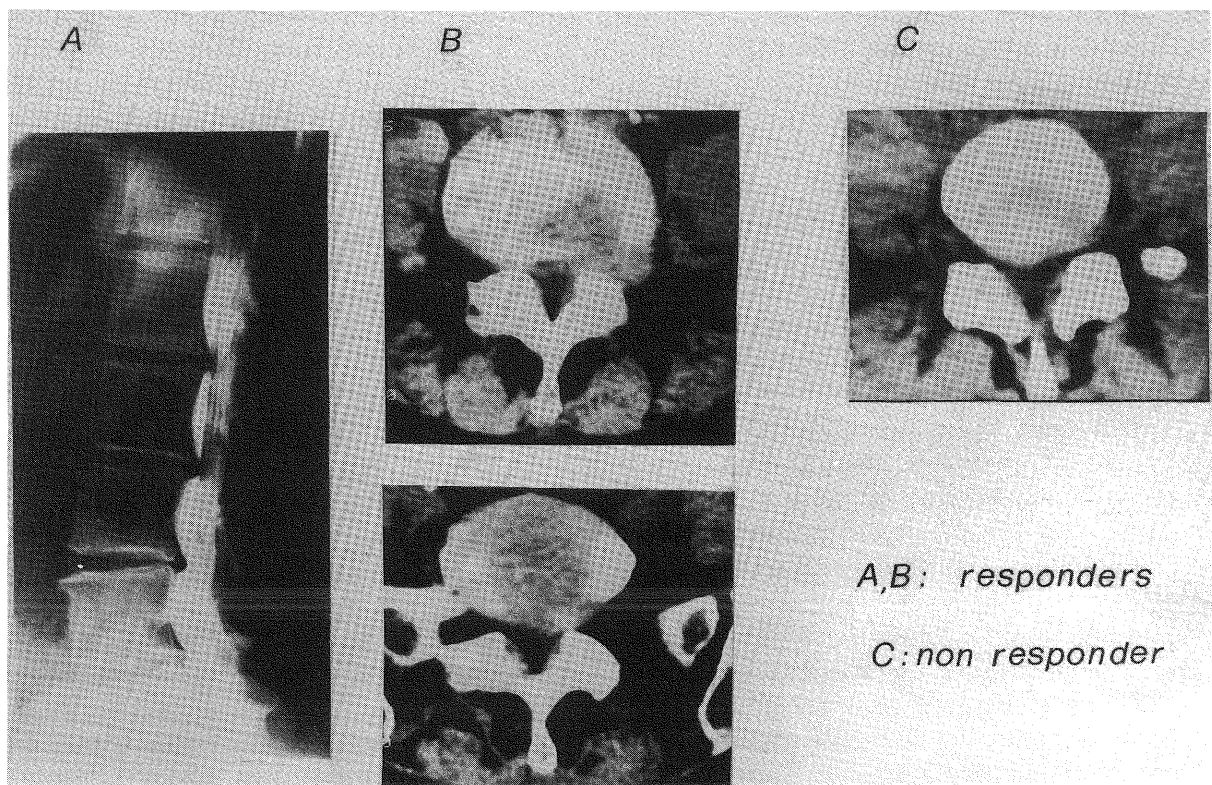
The severity of the radiological picture was not predictive of the outcome after autotractive treatment for low back pain. Subjects A and B were responders, whereas C was not. In A, the myelogram shows a prolapse of the first to fourth lumbar discs; in B, the CT scans show left intraforaminal herniation of the fourth lumbar disc plus spinal stenosis (upper scan), and left mediolateral prolapse of the fifth disc (lower scan). In C, the CT scan shows a mild left mediolateral protrusion of the fourth lumbar disc (from Tesio L., 1989, with permission).
